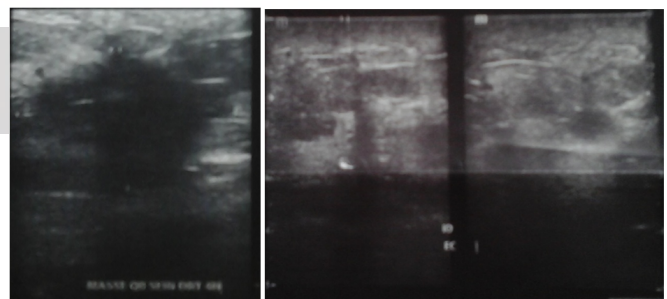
37 years old. Ultrasound: hypoechoic mass of right QII of irregular shape, with indistinct contours, orientation not parallel to the skin covering, with posterior attenuation. Skin thickening and diffuse edema: carcinomatous mastitis.
